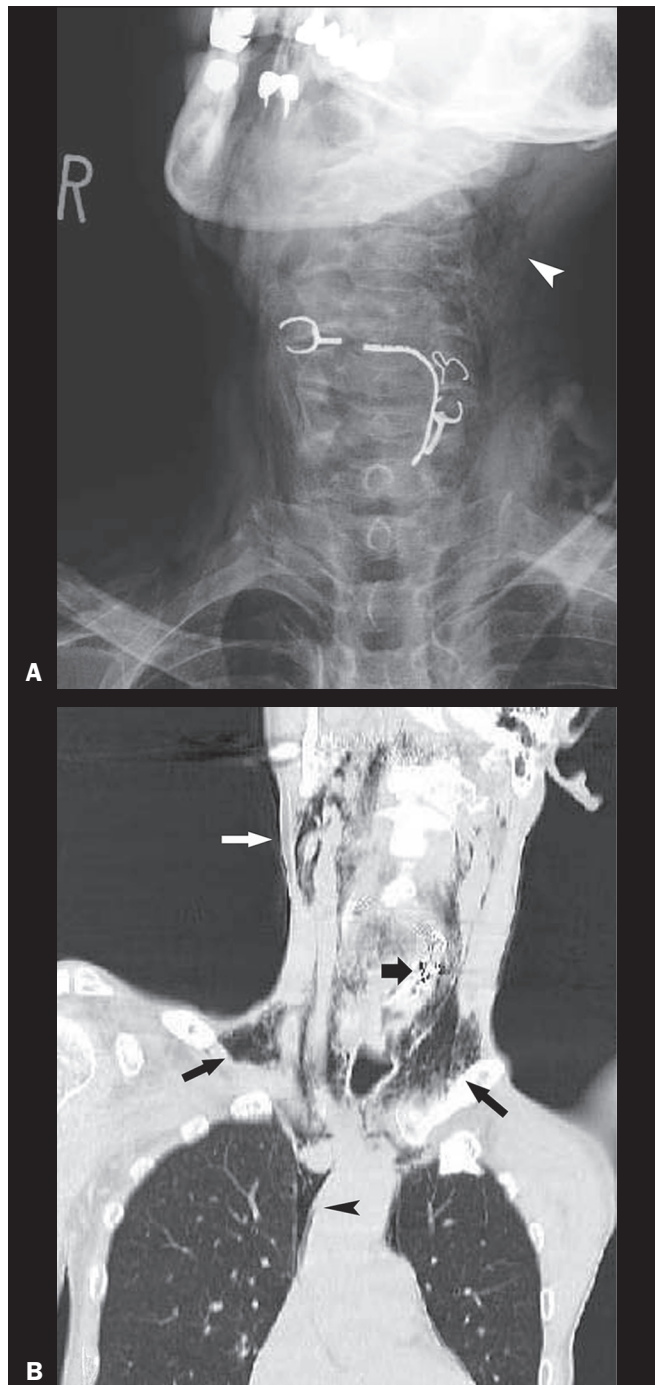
A 60-year-old man who presented with choking after having accidentally swallowed hooks and wires of a broken denture. A: Frontal radiograph of the neck showing the dislodged metallic dental prosthesis that has migrated from the mouth to the cervical esophagus, together with soft tissue emphysema indicating rupture of the esophagus (arrowhead). B: Coronal reformatted CT image (lung window) showing the metallic FB (thick arrow) in the neck, with soft tissue emphysema (white arrow) extending to the bilateral supraclavicular fossae (black arrows). Pneumomediastinum (arrowhead) is also seen.
